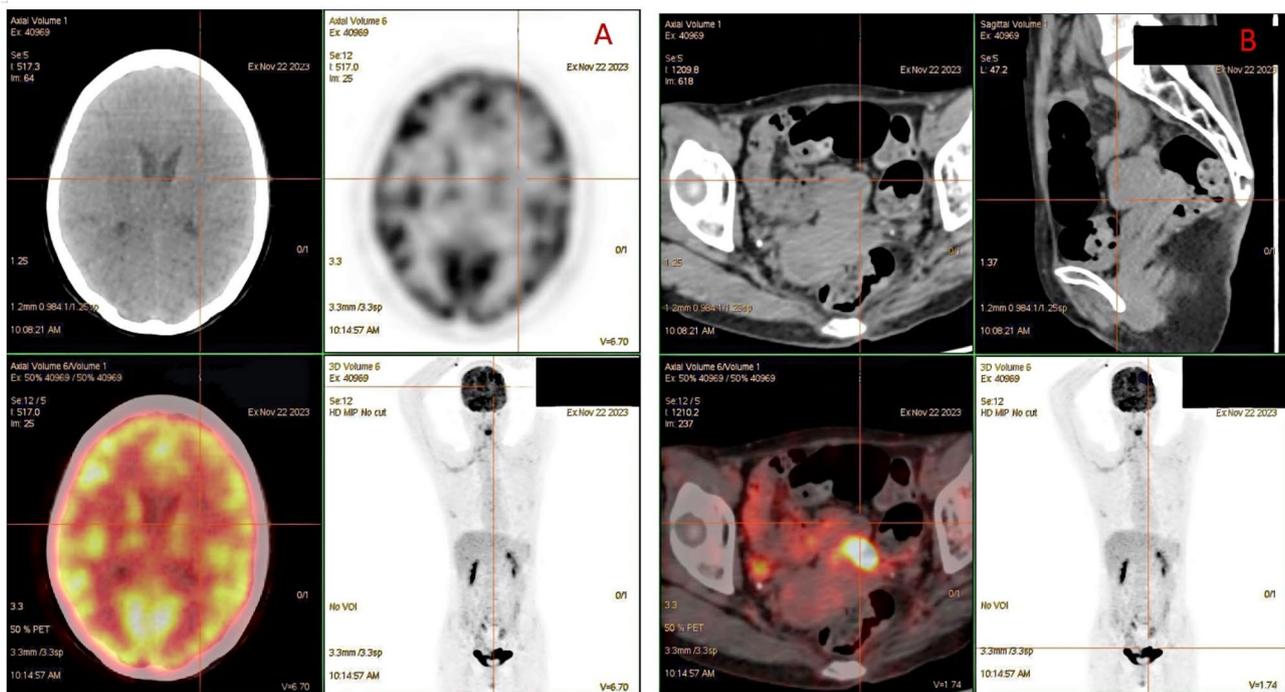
PET-CT Findings. Fig. 4A shows multiple slightly hypodense lesions within the brain parenchyma, which exhibit symmetrically increased FDG metabolism. Fig. 4B shows multiple enlarged lymph nodes adjacent to the right iliac vessels, exhibiting increased FDG metabolism.
